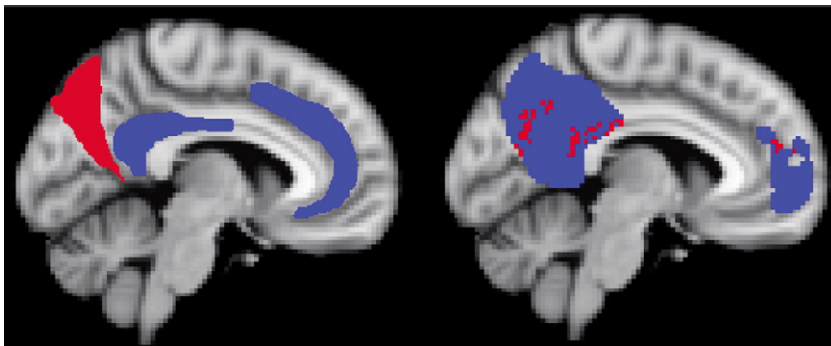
Left: the association cortex as shown in Fig. 15.47B in Nieuwenhuys et al. (2008) is plotted on the medial view of an anatomical MRI scan. The red area indicates the heteromodal association area (HAA) of the parieto-occipital sulcus and the blue areas indicate part of the paralimbic association cortex (BA23 and BA32). Right: Hubs found using betweenness centrality. In this panel, blue shows the DMN, and red, the hubs. It can be seen that the hubs are located in the association areas as indicated in the left figure. Of the two hubs in the Pc/PCC of the DMN, one hub is located within the parieto-occipital HAA (red) and the other hub in the paralimbic association cortex (blue). The hub in the frontal lobe (BA32) is located in the paralimbic association cortex.
